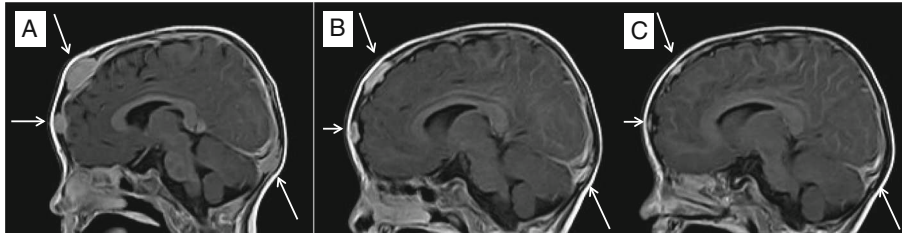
MRI Sagittal view (seq. esT1W_3S_FFE post-contrast). Frontal and parieto-occipital lesion (bars). a Before sunitinib treatment. b Day + 56 of sunitinib. c Day + 156 of sunitinib
